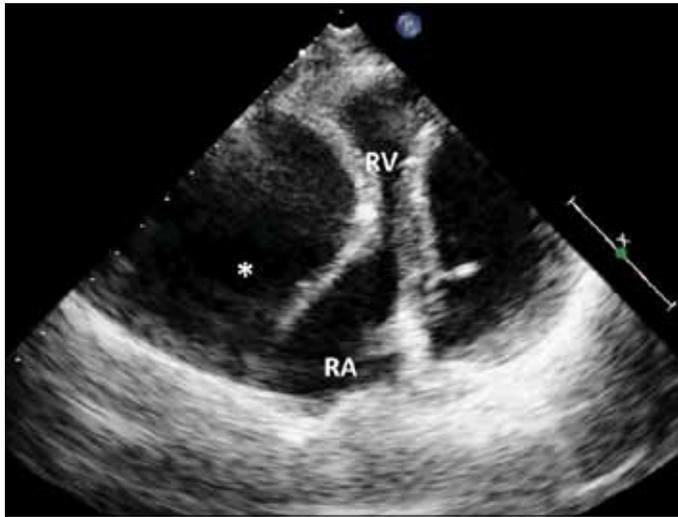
Transthoracic echocardiogram in the off-axis parasternal view revealed a larger cystic mass
